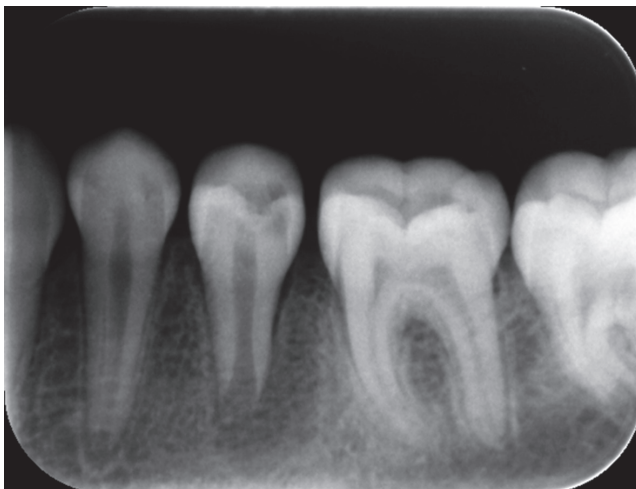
Radiographic examination showed an immature tooth and radiolucent lesion at the periapical area of the root
